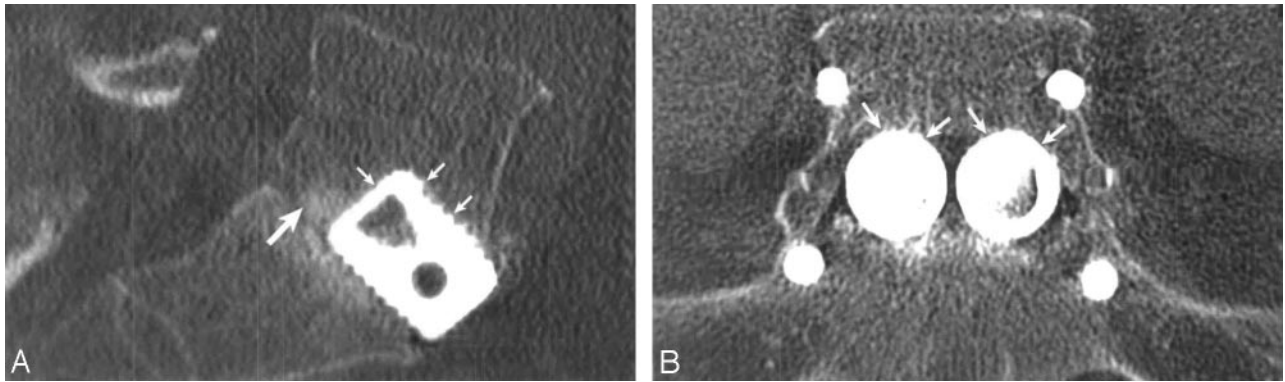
Subsidence of LT-CAGE devices at L5-S1. Sagittal (A) and coronal (B) reformatted CT images demonstrate subsidence of the LT fusion devices (small arrows) through the L5 inferior endplate into the vertebral body in a 60-year-old man. The sagittal image demonstrates new bone formation (large arrow) posterior to the fusion device with bony bridging taking place across the disk space.
